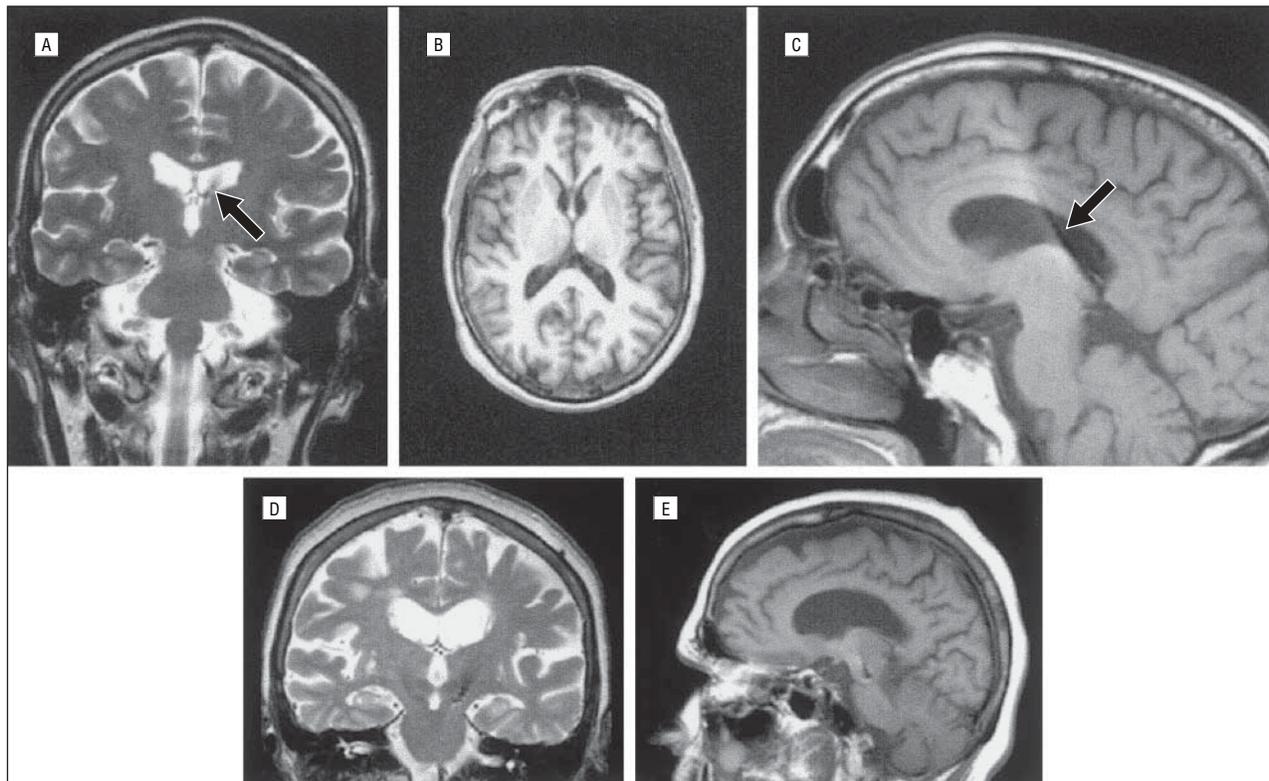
Examples of misplaced deep brain stimulation (DBS) leads. A, Case 1. The coronal magnetic resonance image (MRI) reveals the lead in the ventricle. B, Case 1. The lead is not visualized on the axial sections. C, Case 1. The sagittal MRI reveals that the lead was in the ventricle and lying on top of the thalamus. (Case 1 had a diagnosis of essential tremor, which failed to respond to DBS programming; subsequent reimplantation in the thalamus led to marked resolution of the tremor.) D, Case 2. The sagittal MRI reveals a lead that was deep and posterior to the intended subthalamic nucleus target for tremor. E, Case 2. The coronal MRI reveals a misplaced lead. Lead measurements relative to the midcommissural point were done to assist in confirming lead misplacement. Case 2 lead measurements reveal that the lead was misplaced posterior and deep. The deep contact measured anteroposterior coordinate (AP) -8.9 , lateral coordinate (LT) 8.6 , and axial coordinate (AX) 12.2 ; the 1 contact, AP -7.4 , LT 9.9 , and AX 9.9 ; the 2 contact, AP -6.0 , LT 11.1 , and AX 7.6 ; and the 3 contact, AP -4.5 , LT 12.4 , and AX 5.3 . Lead misplacement was confirmed by a combination of clinical response, thresholds for adverse events, imaging, and discussions by the neurologist and neurosurgeon.
